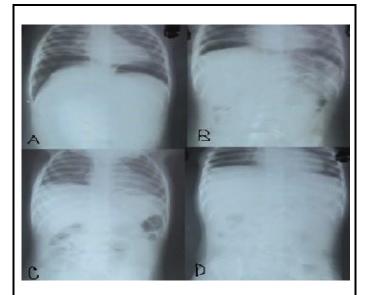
A series of straight abdominal X-rays show huge pneumoperitoneum (free gas under diaphragm) following colonoscopic rectal polypectomy and gradual resolution of pneumoperitoneum with conservative management. (A, B, C, and D: on admission, 3rd, 6th, and 9th day from admission respectively.)
